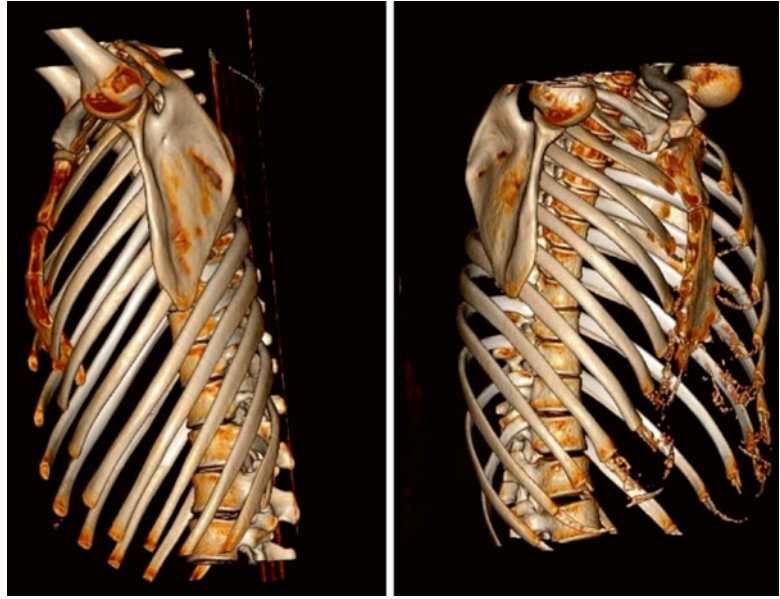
CT scan with minimal depression and displacement
